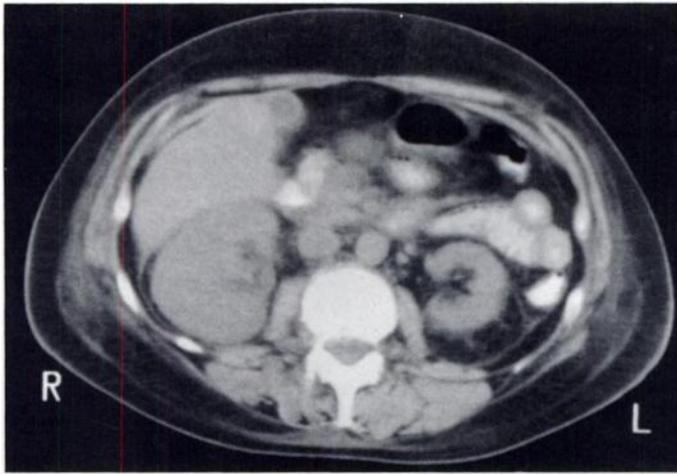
CT of abdomen demonstrating marked nephromegaly of right kidney compared to left.
